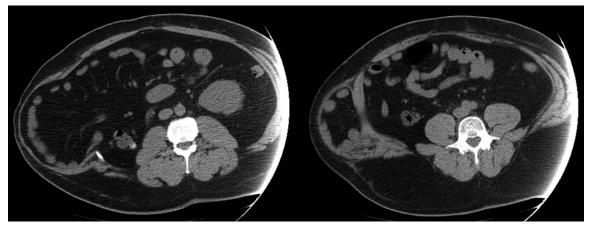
(*Left*) On most cuts of this computed tomographic scan, the patient appears to have a true hernia or bulge alone (the patient also has a midline hernia). (*Right*) Careful examination reveals the external oblique to be intact and stretched, with the internal oblique and transversus muscles retracted.
